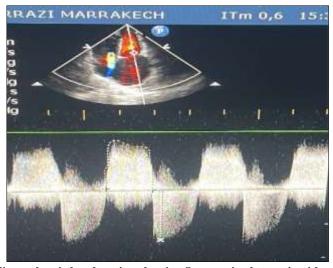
Transthoracic echocardiography; 4 chamber view showing Severe mitral stenosis with a high gradient of 53 mmHg and moderate mitral regurgitation
